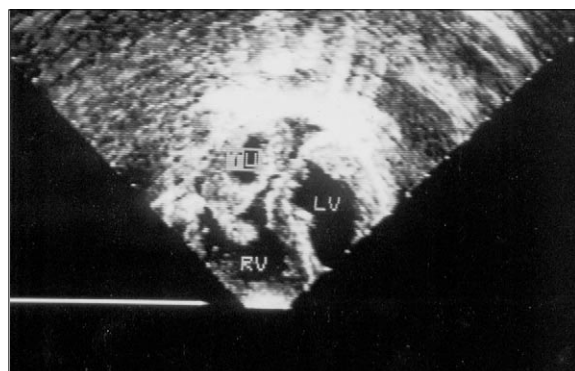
Transthoracic ECHO (four-chamber view). Opacification of the right atrial chamber by tumor masses and protrusion into the right ventricular inflow during diastole. LV – left ventricle. RV – right ventricle. TU – tumor mass.
